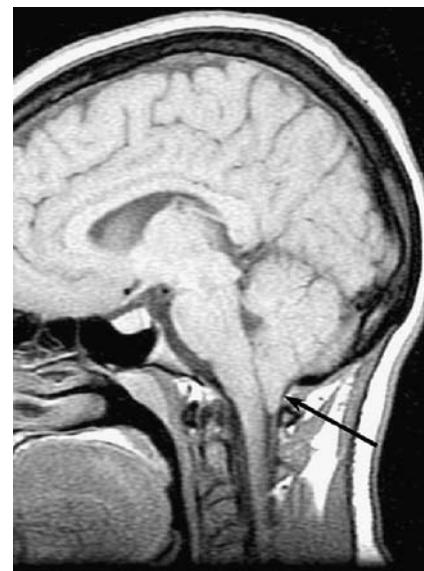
Chiari I malformation. Sagittal T1-weighted MR image demonstrates herniation of the cerebellar tonsils (arrow) below the level of the foramen magnum. Tinnitus is among the many clinical manifestations of this abnormality
